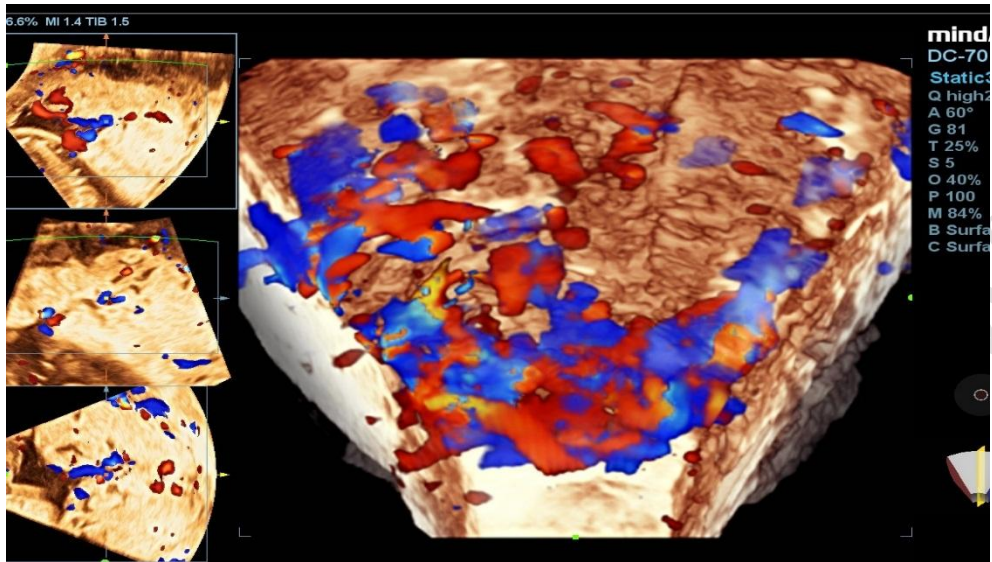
Placenta lacunae as seen with color Doppler.
